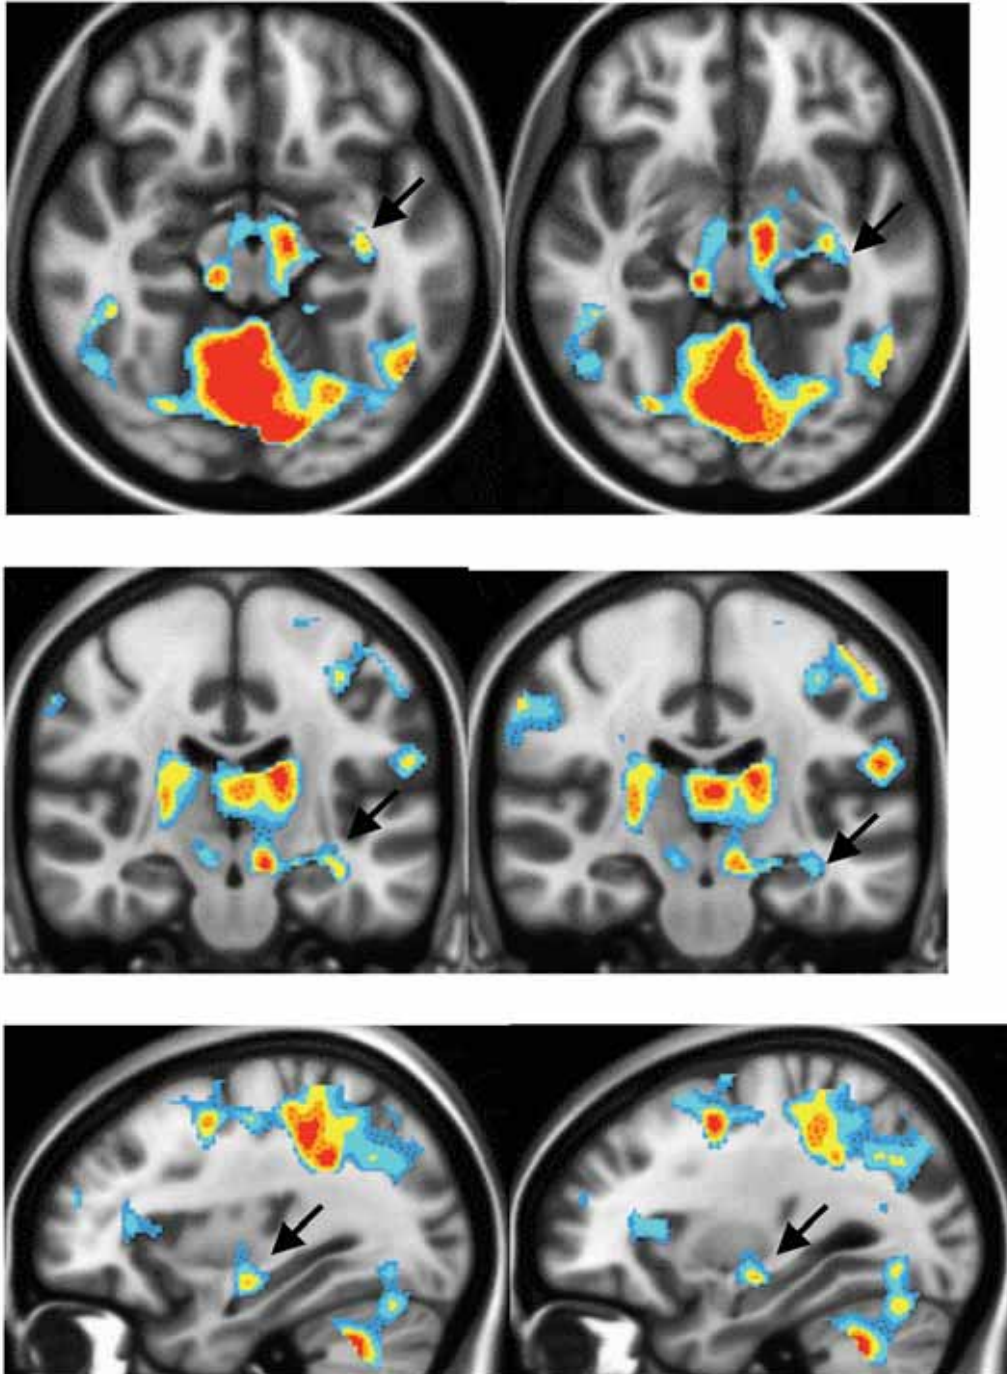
Results at hippocampus level during abstract picture recognition are displayed as color overlays on axial (A), coronal (B) and sagittal (C) views of T1-weighted images. Intensity of activation was displayed as color, gradual change from dark blue (less activity) to red (strong activity). The pictures showed activation at the anterior aspect of left hippocampus (black arrow). Note no activation of the right hippocampus.
